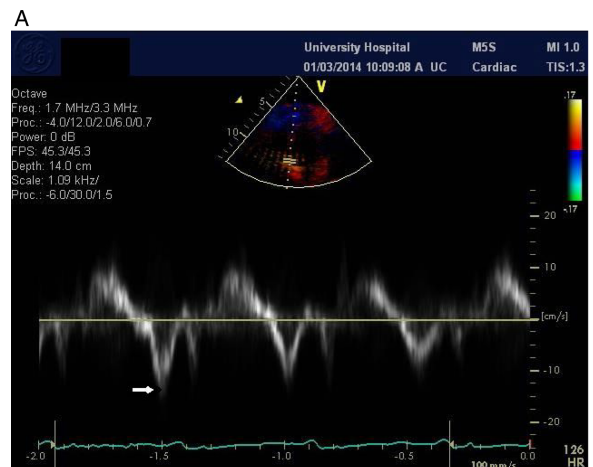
(A and B) Tissue Doppler of the velocity of the septum versus the lateral wall. The velocity of the septum (A) was increased compared to the velocity of the lateral wall (B) (arrows).
